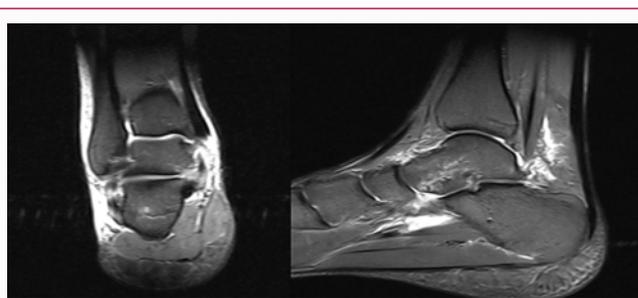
Lack of both osseous pathology and osteochondral lesions on the MRI.
